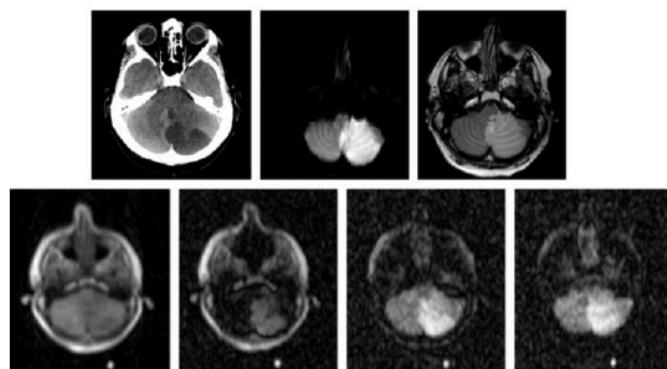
Images of brain stroke from CT (top left), DWI at 3 T (top middle) and T2 at 3T (top right), as well as FFC-MRI at 200, 20, 2 and 0.2 mT (bottom line). A contrast is clearly visible down to the lowest attainable field.
